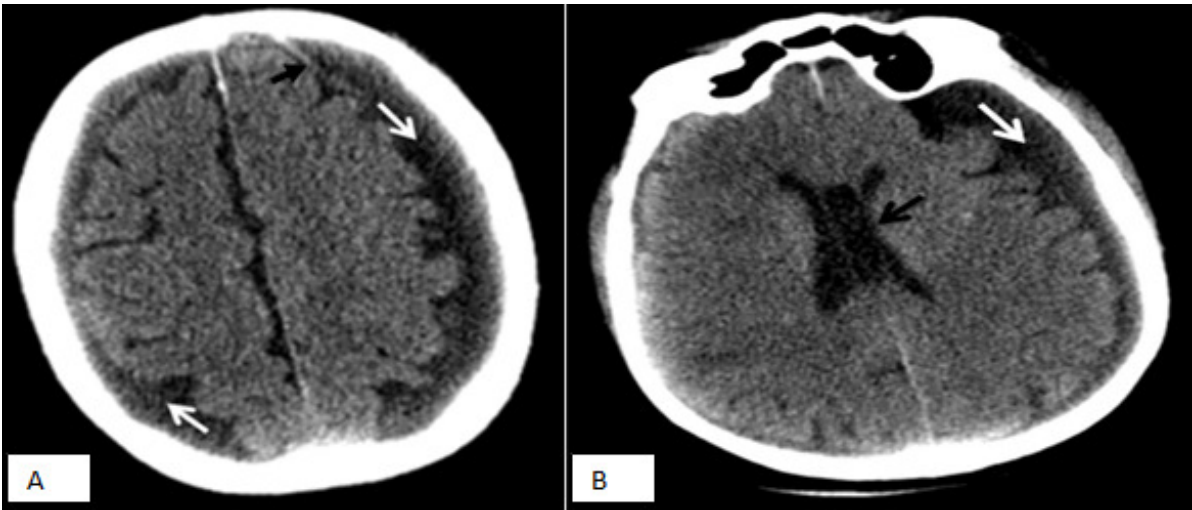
CT images 1 week after the trauma show bilateral newly developed hypodense SDF collection (A, B, white arrows) on the cerebral convexities which is more prominent on the left side and associated with compression of the adjacent brain (A) and a slight ventricular compression (B, black arrow) without midline shift. Note the presence of vessel crossing the SDF collection (A, black arrow)
